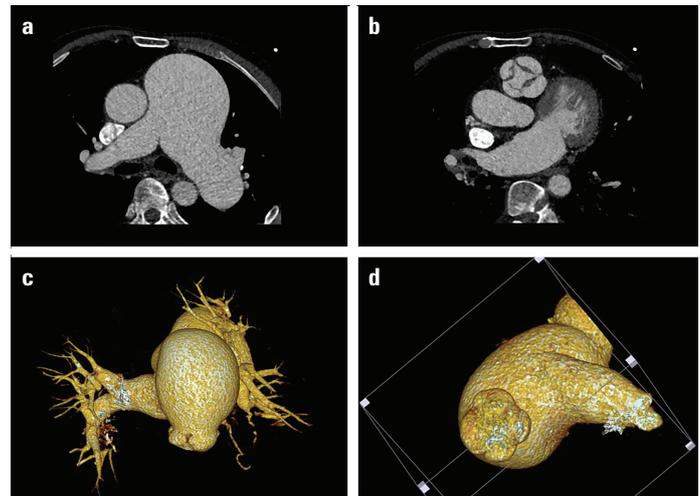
The computed tomography angiography (CTA) and three-dimensional volume-rendered computed tomography (3D VR CT). Axial image of the chest at the level of the bifurcation of the main pulmonary artery showed aneurysmal dilation of the main (73 mm) and left (43 mm) pulmonary arteries, while the right pulmonary artery was seen slightly dilated (31 mm) (a). Reconstructed CTA of the chest at the level of pulmonary valve demonstrated a quadricuspid pulmonary valve with four cusps of similar size (b). 3D VR CT confirmed that quadricuspid pulmonary valve had four cusps of similar size and showed the great aneurysm of the pulmonary artery intuitively (c and d)
